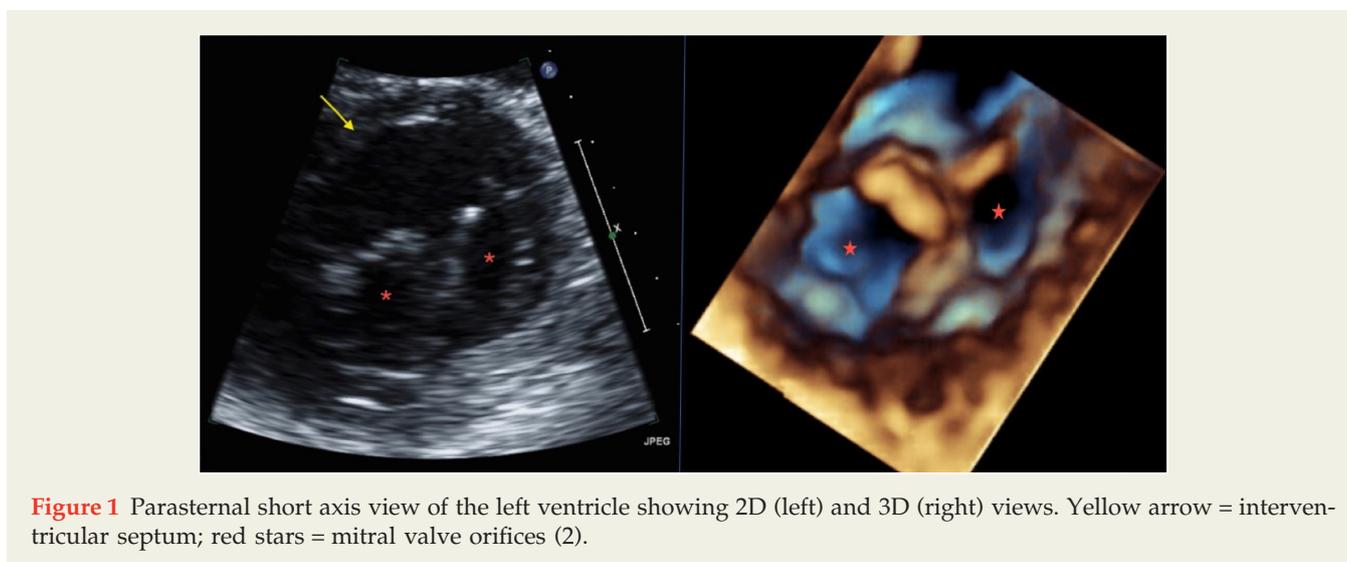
Parasternal short axis view of the left ventricle showing 2D (left) and 3D (right) views. Yellow arrow = interventricular septum; red stars = mitral valve orifices (2).
